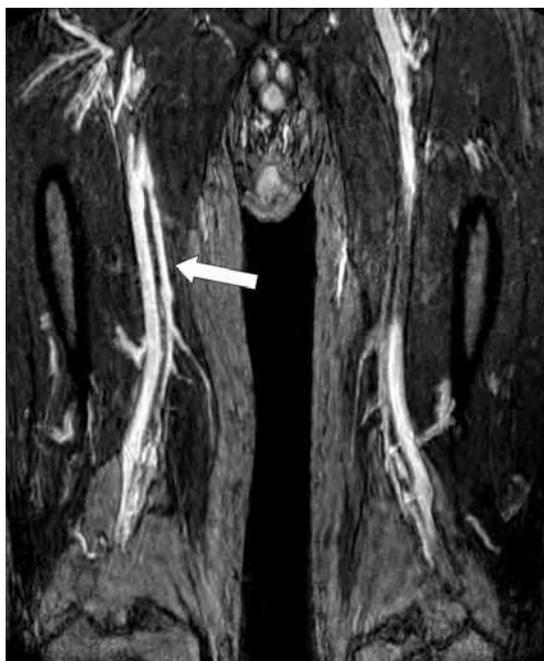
High resolution MRI in the coronal plane showing duplication of the superficial femoral vein (*arrow*). Note that the superficial femoral artery is not visible because it was occluded at the groin. The patient had known claudication.
